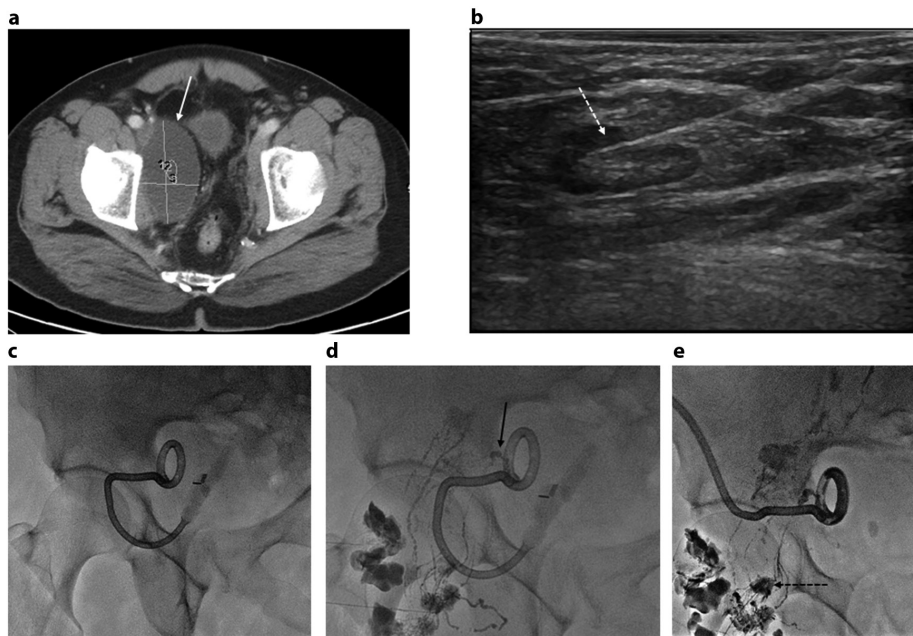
A 61-year-old male with a history of prostatectomy and pelvic lymphadenectomy presenting with pelvic pain and right lower extremity edema. (a) Computed tomography of the abdomen and pelvis showing right pelvic fluid collection (white arrow) compressing the external iliac vein. Consistently high output of the drain noted (200 cc/day). (b) Ultrasound-guided access in one of the right inguinal lymph nodes with the needle tip placed at the corticomedullary junction (dotted white arrow). (c, d) Fluoro spot images before and during intra-nodal lymphangiography showing the focal area of contrast extravasation within the expected location of the collection (black arrow). Leak confirmed by flushing and aspirating the drain (not shown). (e) Access obtained under fluoroscopy to the lymph node closest to the leak (dotted black arrow). Position confirmed by injecting 5% dextrose, and then embolization was performed with 0.33 cc of n-butyl cyanoacrylate/lipiodol mixture (1:4). The output dropped, and the drain was removed 7 days later.
